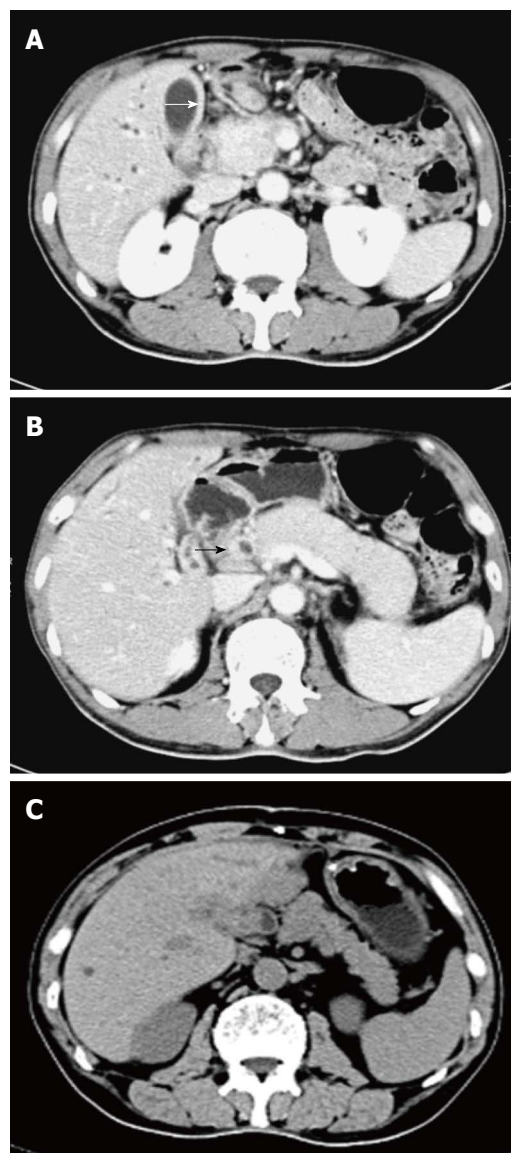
Computed tomography images of autoimmune cholecystocholangitis and pancreatitis. Diffuse gallbladder wall thickening (white arrow) and intrahepatic bile duct dilatation (A), thickening of the common bile duct wall (black arrow) and diffuse swelling pancreas with loss of lobulation (B), and a dramatic recovery in the size of the pancreas after 4 wk of steroid therapy (C).
